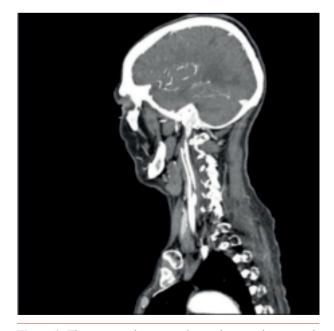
The computed tomography angiogram shows an ulcerated plaque at the right internal carotid artery bulb.
